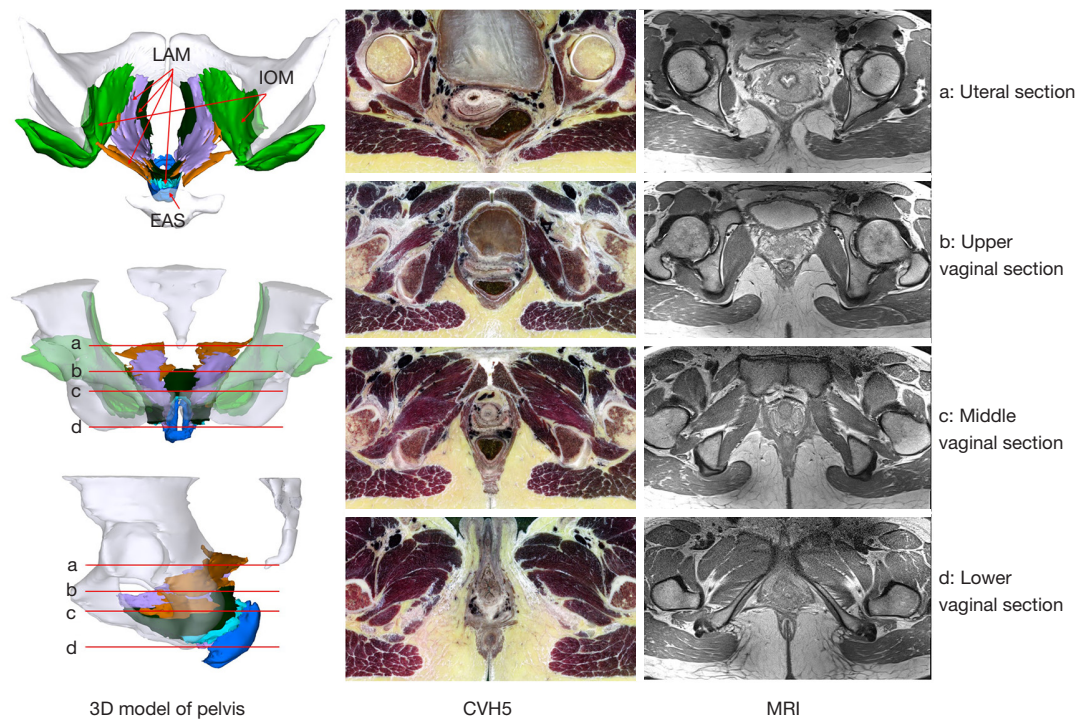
The connections and orientation of the 3 pelvic floor muscles. Column 1 displays different 3D views of CVH5 pelvis, column 2 shows different slices of CVH5 pelvis including the uteral, upper vaginal, middle vaginal, and lower vaginal section, column 3 shows the MR images of corresponding sections in 1 normal case. a: uteral section. b: upper vaginal section. c: middle vaginal section. d: lower vaginal section. LAM, levator ani muscle; IOM, internal obturator muscle; EAS, external anal sphincter; 3D, 3-dimensional; CVH5, the fifth Chinese Visible Human dataset; MRI, magnetic resonance imaging.
